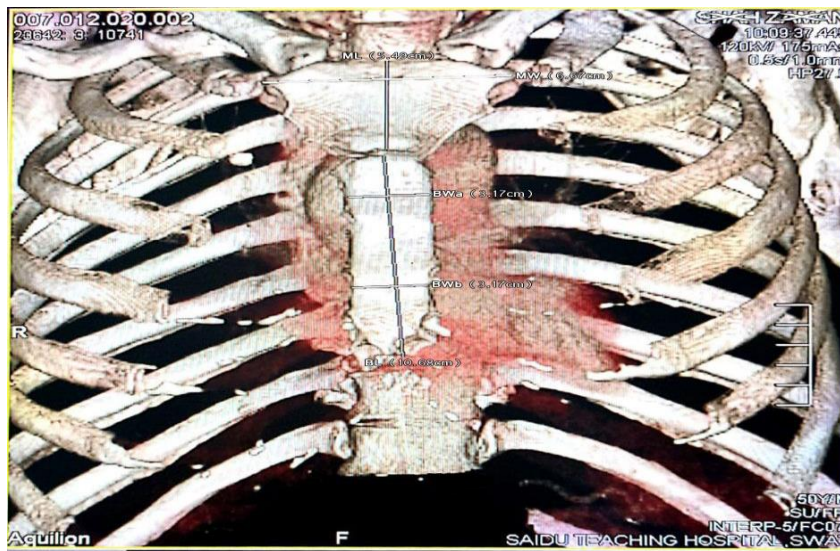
Measurement of the sternal wall dimensions of male on computed tomography
